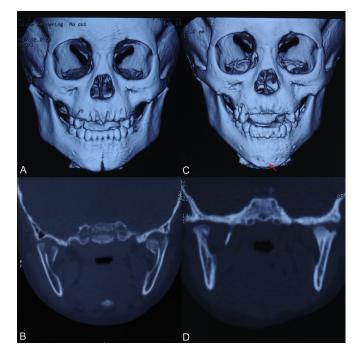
A 4-year -old girl sustained symphysis and bilateral condylar fractures from a traffic accident. (A, B) Preoperative CT of the fractures. (C) The symphysis fracture was fixed with an absorbable plate on the inferior border of the mandible. A 3-dimensional CT scan 3 months after the operation revealing well fracture healing (red arrow). (D) Coronal CT 3 months after the operation showing remodeling of the bilateral condyles after conservative treatment.
